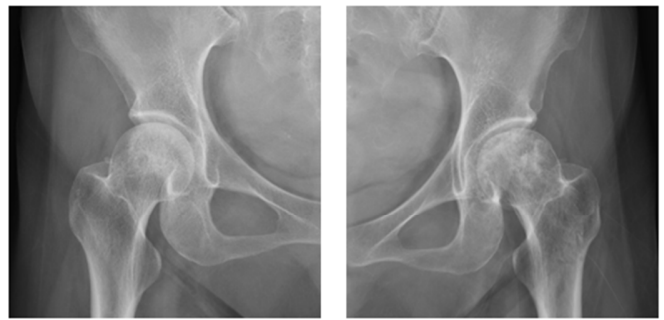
Hip X-ray data sample.
